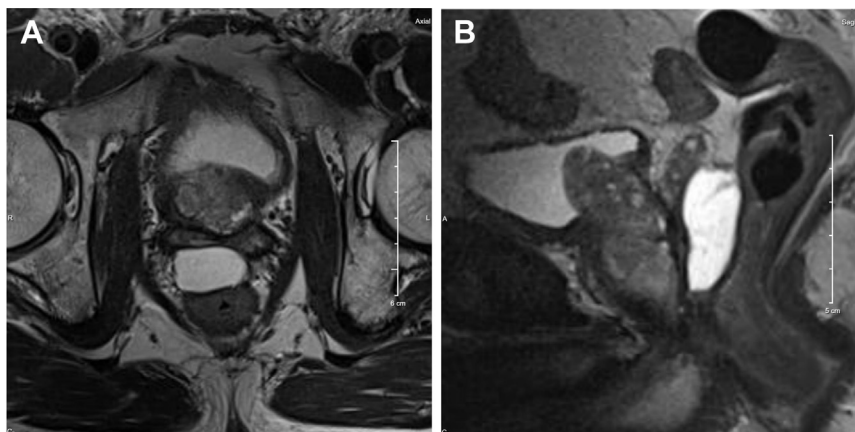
(A) Axial MRI image demonstrating absorbable hydrogel spacer (SpaceOAR) situated between rectum and prostate/seminal vesicles (Case 2). (B) Sagittal MRI image demonstrating absorbable hydrogel spacer (SpaceOAR) situated between rectum and prostate/seminal vesicles (Case 2).
